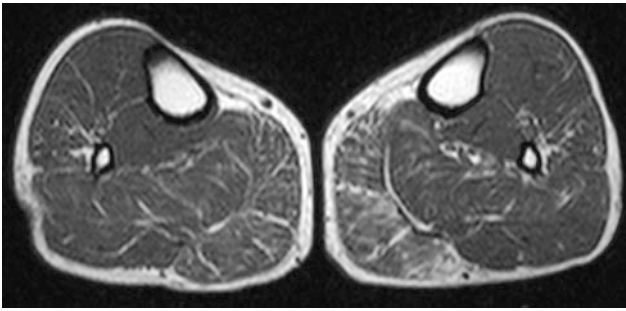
Axial T1-weighted images of the lower legs showing the beginning of preferential and asymmetric fatty infiltration of the medial gastrocnemius muscle, most pronounced on the left side, in inclusion body myositis
